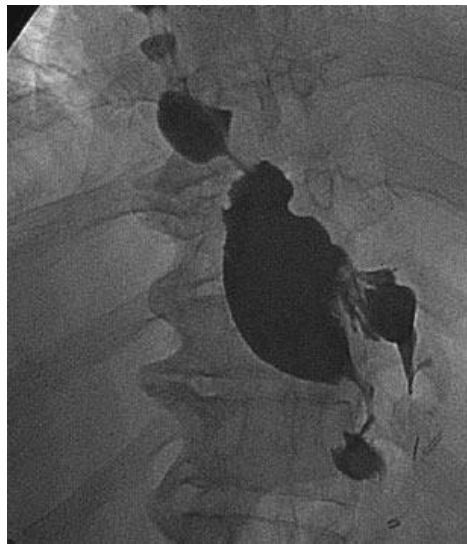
Upper GI contrast X-ray after sleeve gastrectomy reveals organic stenosis and gastric leak. Prestenosis Segment Dilation (22).
